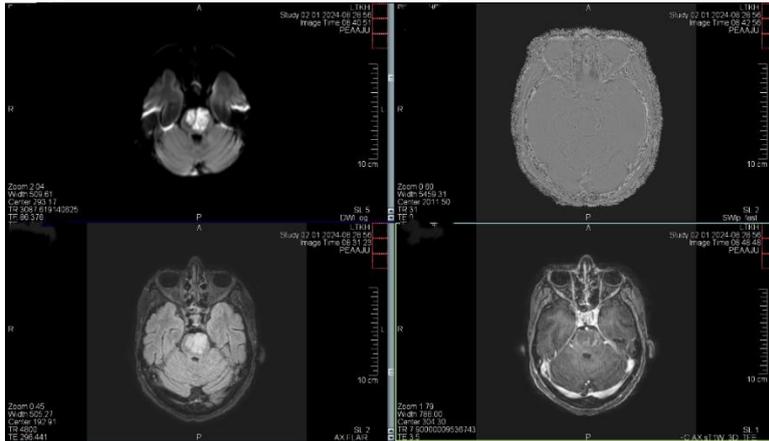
Third MRI scan showing ischemic lesion's progression in the brainstem.
